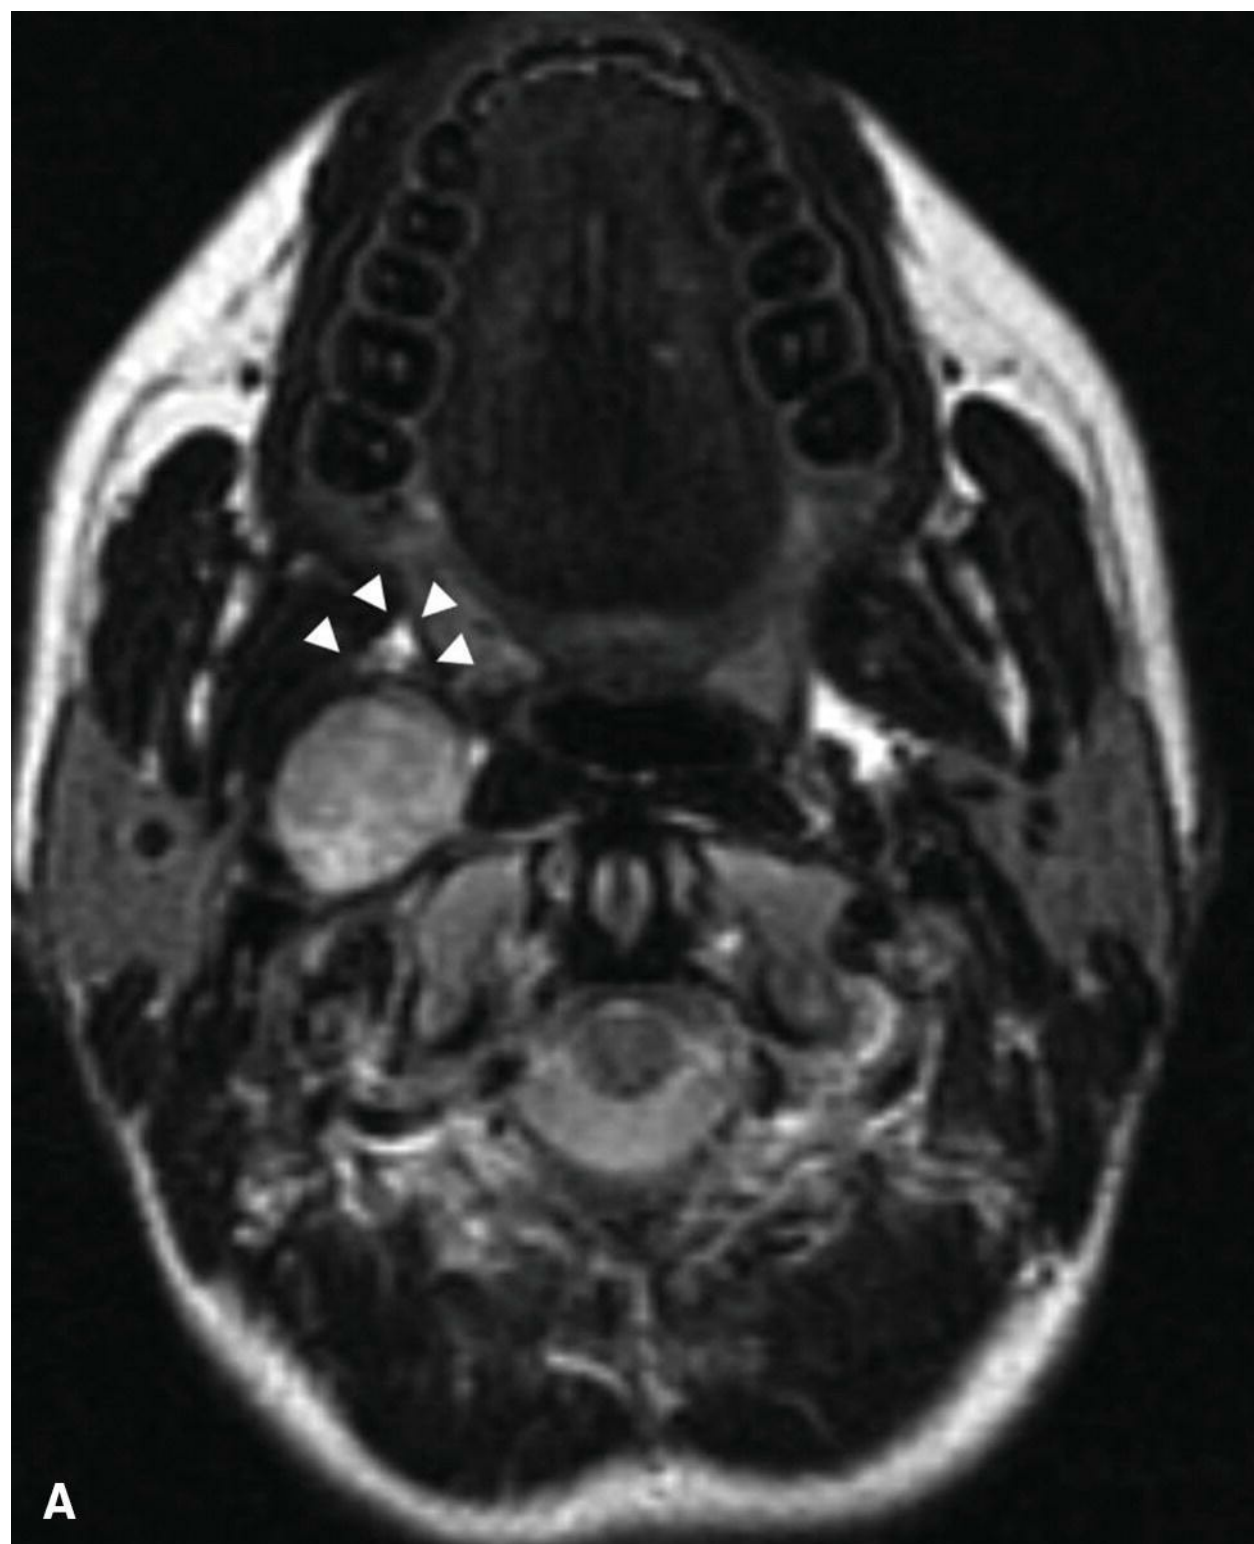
Schwannoma (cystic). A 57-year-old woman with a PPS mass incidentally noted on spinal MRI. Ring enhancing, a primarily cystic mass
